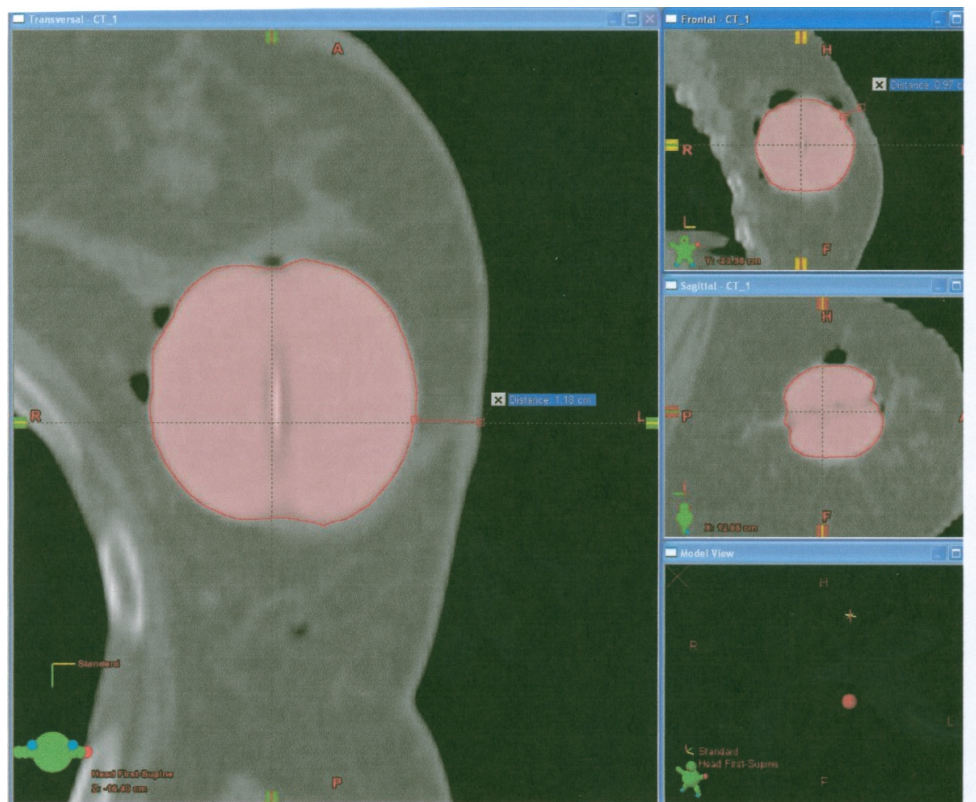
This figure shows the measured distances from the balloon's surface to the skin in three different orientations. Shown are the CT slices with the shortest distances. Frontal view shows the shortest distance of 9.7 mm which is beyond the acceptable minimum distance of 5 mm.
